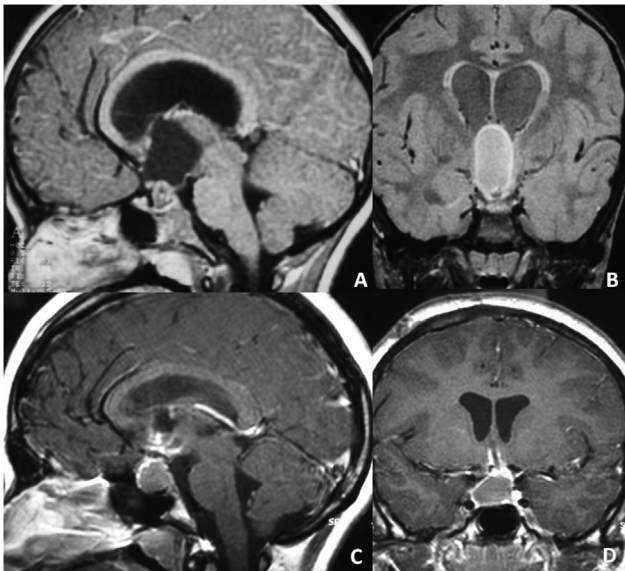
Case 2. An MRI scan showing the cystic craniopharyngioma: (A) sagittal T1-weighted image; and (B) coronal fluid-attenuated inversion recovery (FLAIR) before treatment. Control MRI 48 months after the treatment: (C) sagittal T1-weighted image; and (D) coronal T1-weighted image showing complete obliteration of the cystic portion of the tumor after stereotactic intracavitary irradiation with colloidal ^{186}Re .
